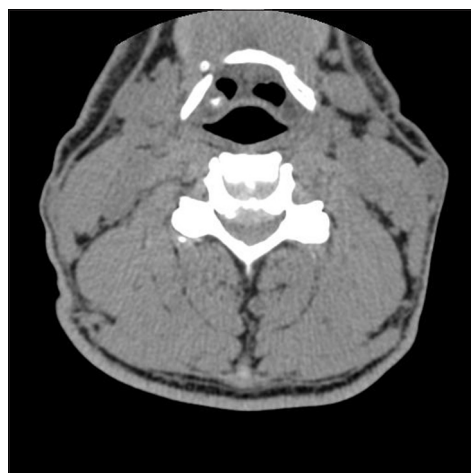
Axial CT image at the C4-C5 disc space following the CSS. This axial noncontrast CT study demonstrated marked stenosis/spondylosis at the C4-C5 level narrowing down the spinal canal to 5–6 mm. Ventrally the hyperdense soft-tissue appears more spondylotic vs. soft disc, while posteriorly the compression was attributed to inward shingling of the C5 lamina. Certainly, both the MR and CT studies help document why this patient, with such severe stenosis at the C4-C5 level, was so susceptible to the CSS cord injury
